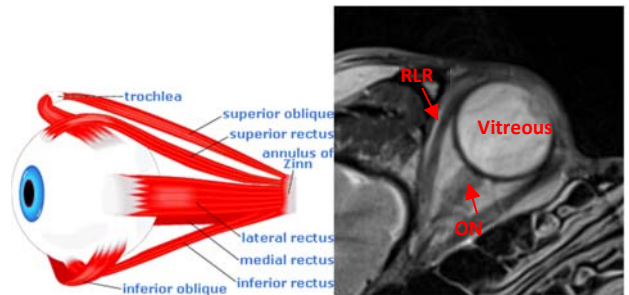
(Left) Extraocular muscles. (Right) T2-weighted axial image of the right eye showing the right lateral rectus muscle (RLR), optic nerve (ON), and vitreous.
